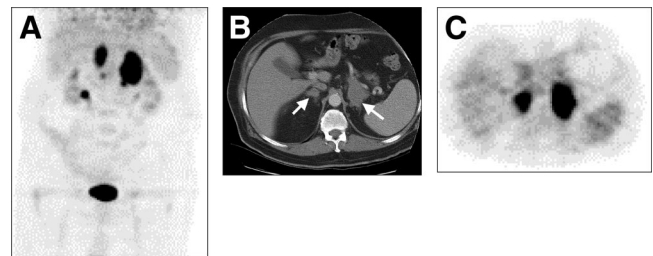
(A) ¹⁸F-FDG PET scan shows intense, bilateral uptake in adrenal masses. (B) CT scan shows bilateral adrenal masses (arrows); left adrenal lesion is larger, with irregular borders. (C) ¹⁸F-FDG PET axial view at same level as for CT shows intense, bilateral uptake in adrenal masses.
